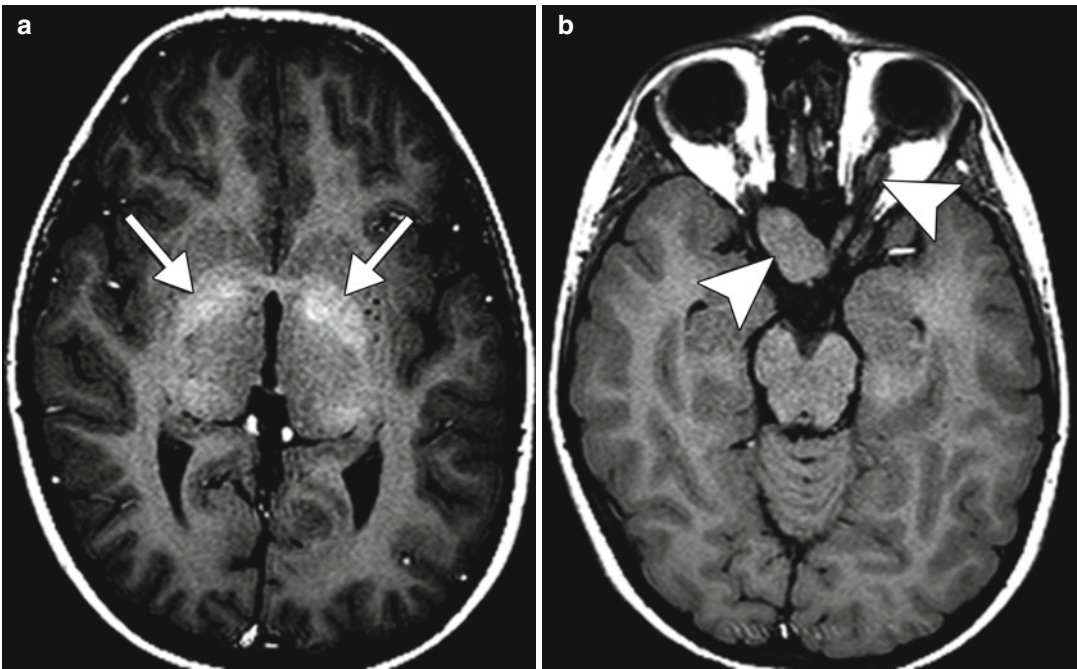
Neurofibromatosis type 1. Axial T1-weighted MR image (a) shows irregular areas of high signal in the bilateral basal ganglia (arrows), bridging across the anterior commissure. Axial T1-weighted MR image (b) shows bilateral optic gliomas (arrowheads)
